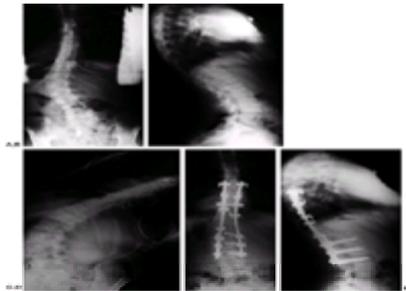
A: This 13-year-old female presented with a progressive left thoracolumbar scoliosis associated with trunk shift to the left. B: The lateral radiograph demonstrates maintenance of relatively normal sagittal alignment. C: Side-bending to the right demonstrates that L3 is level with the top of the pelvis. D: Posterior instrumentation and fusion were performed utilizing pedicle screw fixation through the apex of the lumbar spine at L1, L2, and L3 bilaterally. This provided correction of her lumbar deformity and improved her trunk shift, resulting in a balanced spine. E: Postoperative lateral radiograph demonstrates maintenance of lumbar lordosis in the instrumented segments.
